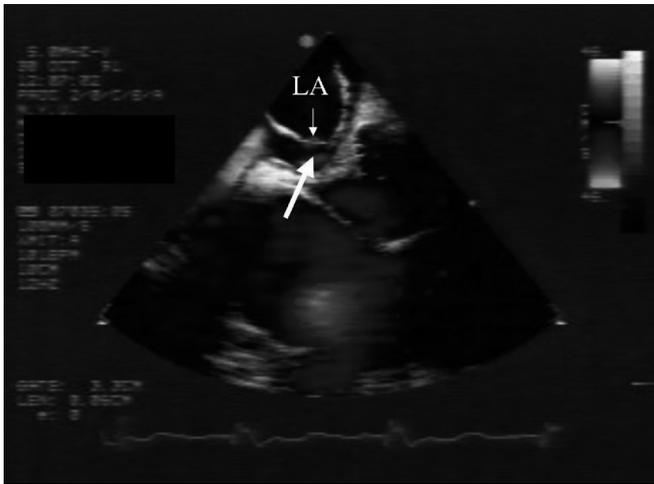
TEE in a 62 year old man with hypoxia. Color Doppler flow imaging during release of the Valsalva maneuver shows higher right atrial pressure, the septum primum (thin arrow) is shifted toward the left atrium (LA) creating a larger PFO diameter (thick arrow). A right-to-left color flow jet is noted.
